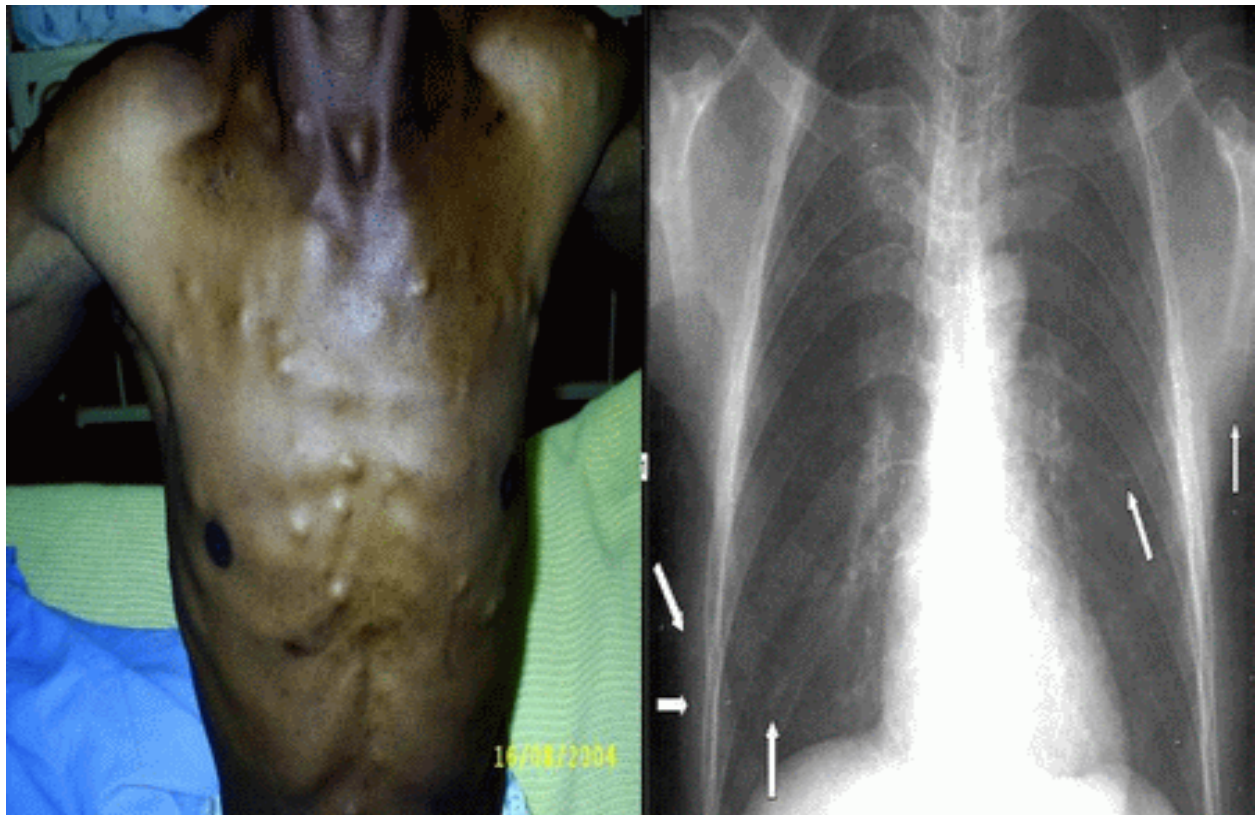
Multiple subcutaneous nodules on the chest wall and a few calcified lesions on chest X-ray. (Photo taken by H Foyaca-Sibat. Source: Foyaca et al., *Rev Electron Biomed / Electron J Biomed* 2004;3:39-43. Written patient consent is obtained).
